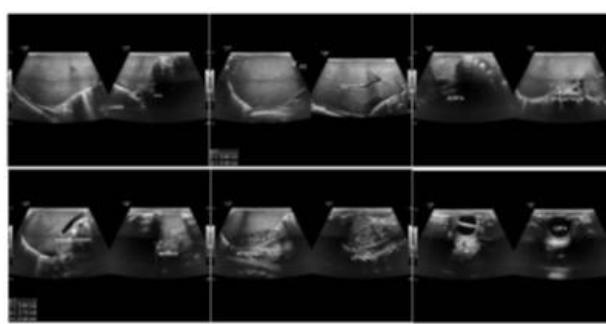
RSMS Abdominal Ultrasound (November 13, 2024)
